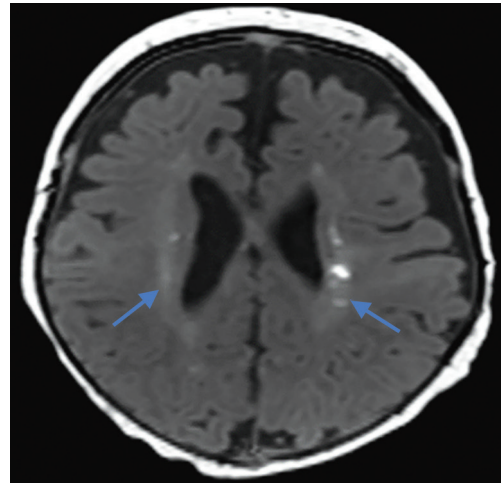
Brain MRI showing bilateral white matter injury
